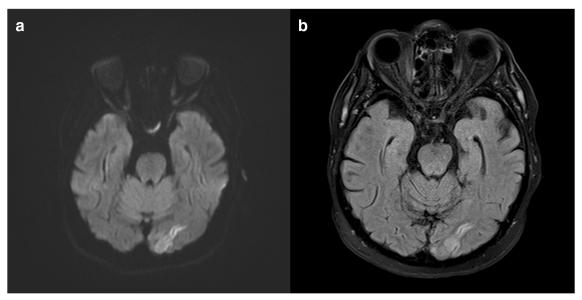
Brain MR showing DWI (a) and FLAIR (b) high signal intensity in the left occipital scissure
